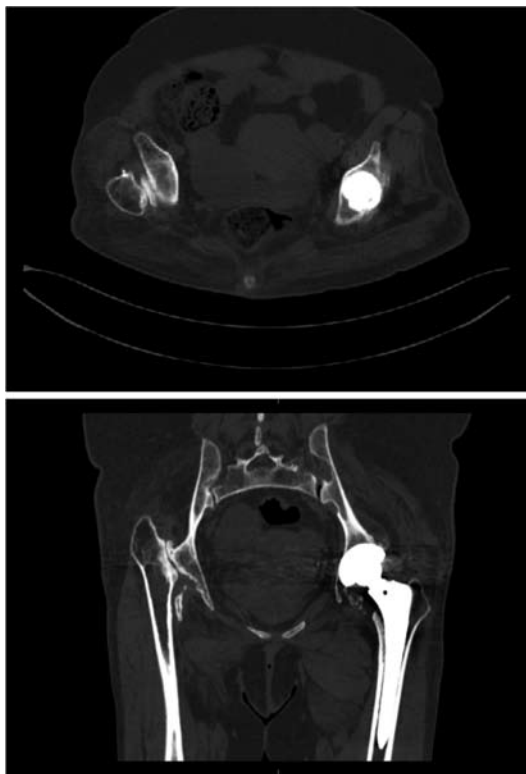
Pelvic CT scans of hips, axial and coronal section: AVN of head and neck of the right femur with prosthetic implant on the left hip (Department of Radiology, Cantonal Hospital Zenica, 2010)
